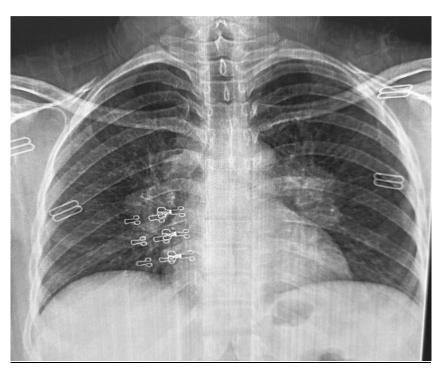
Bilateral hilar lymphoma on a frontal chest radiograph.
